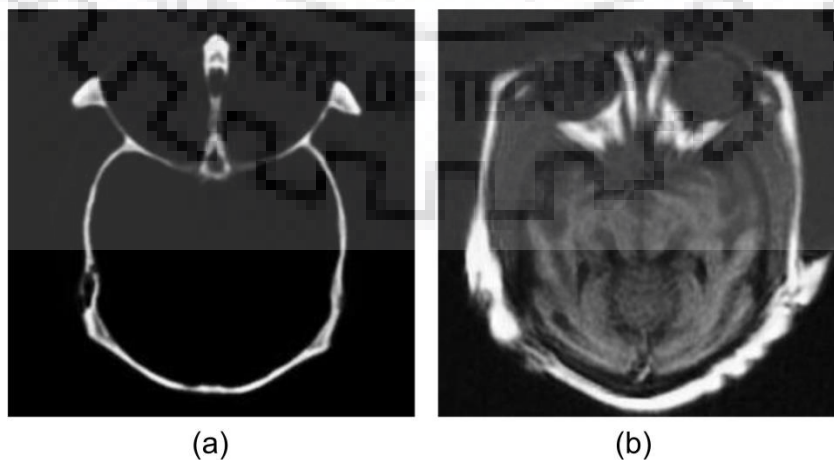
Input reference (a) CT and (b) MR image to evaluate the fusion performance
